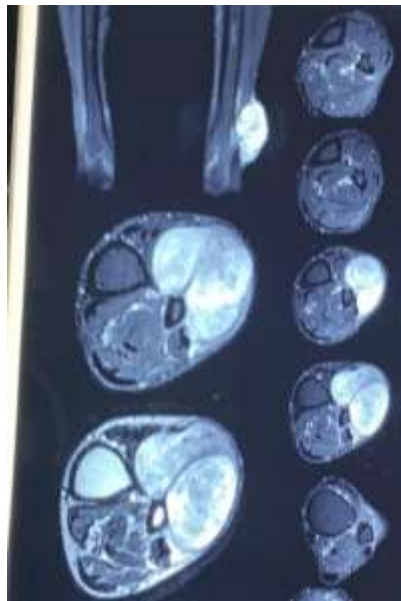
MRI of the lesion
